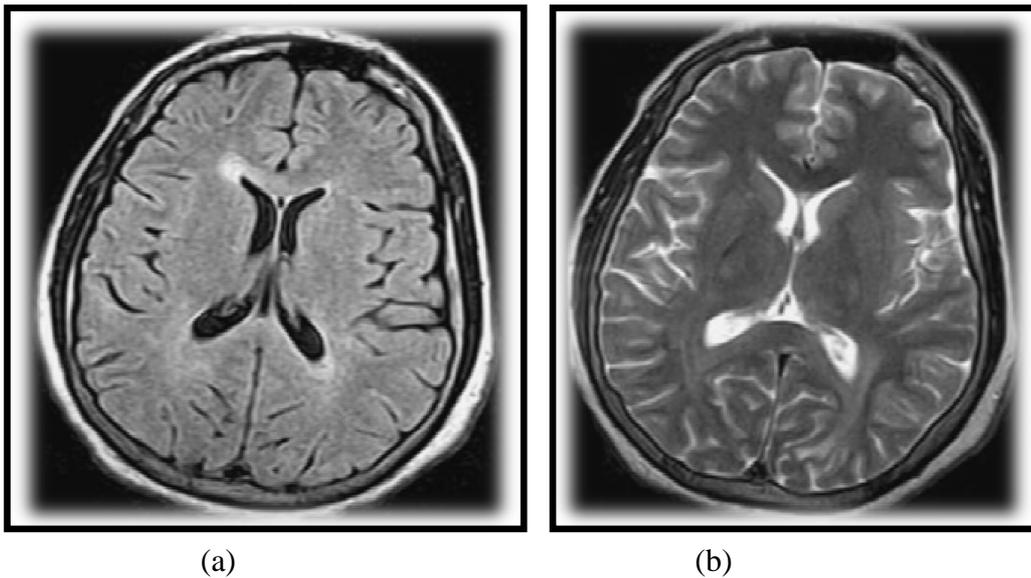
(a) T1-weighted spin echo image of the head. (b) T2-weighted spin echo image of the head. [7]
